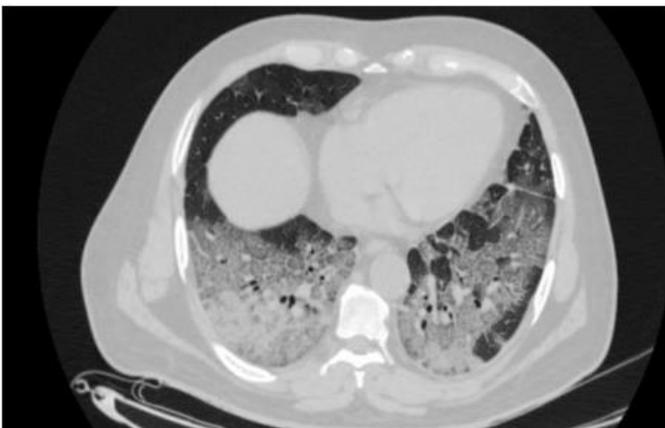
Axial HRCT Thorax lung window in un vaccinated patient showing diffuse areas of ground Glas
